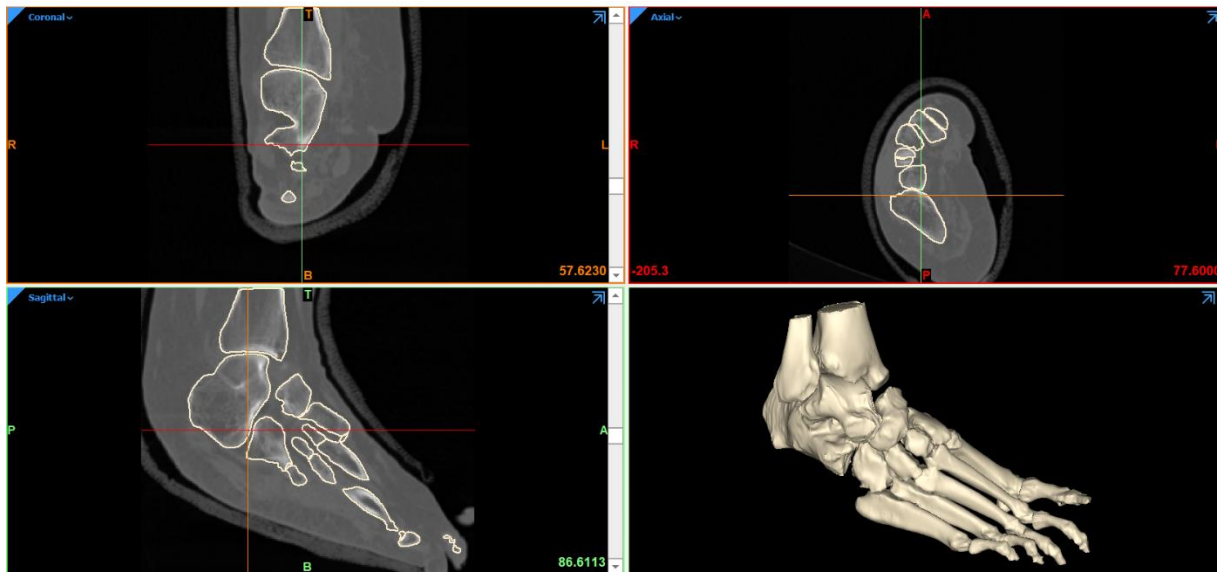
CT data of the preoperative foot of case D, neutrally aligned using a total contact cast. Coronal (top left), Axial (top right) and Sagittal (bottom left) multiplanar reconstructed (MPR) views of CT data. The 3D model constructed from CT data is shown in the bottom right corner.
